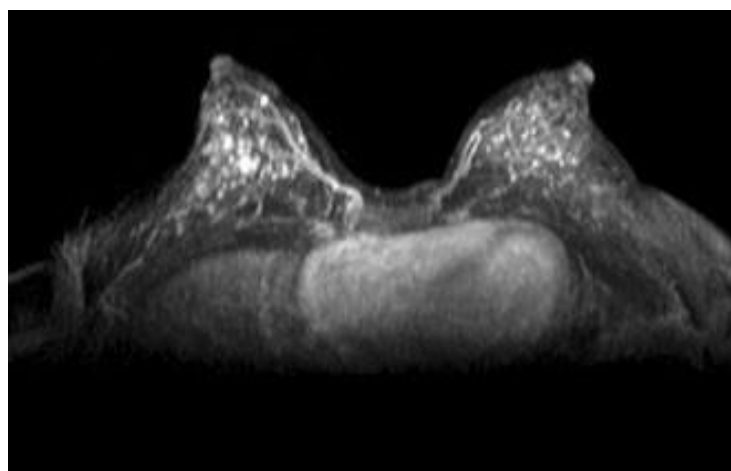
Contrast-enhanced magnetic resonance imaging (Flash3D, MIP) in normal dense breasts. Multiple foci due to spontaneous hormone-induced enhancement are seen (25)
